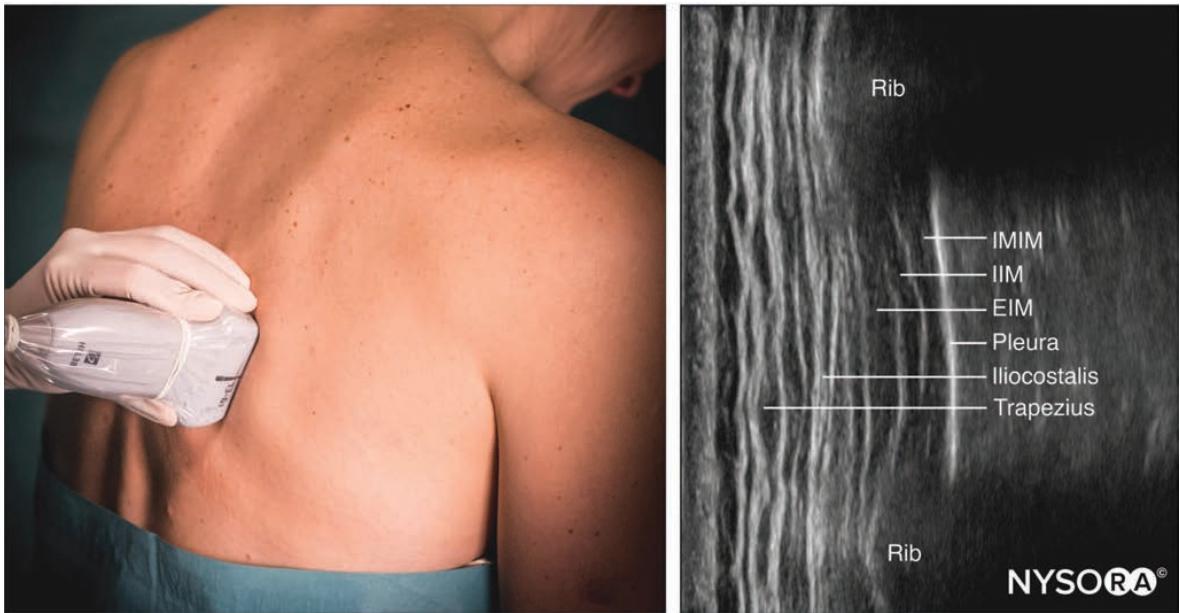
Transducer position and ultrasound image of an intercostal nerve block. EIM, external intercostal muscle; IIM, internal intercostal muscle; IMIM, innermost intercostal muscle.
